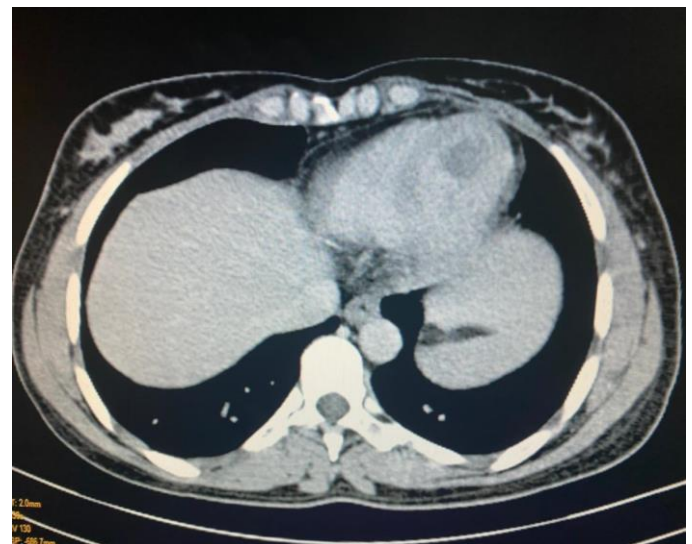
thoracic CT scan showing cardiac metastasis
